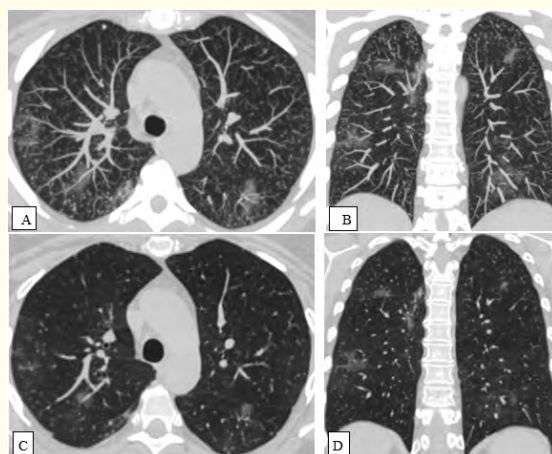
CT image of multiple bilateral areas of "ground glass opacity" and small foci of both lungs: A- Axial plane, MIP mode; B- Frontal plane, MIP mode; C- Axial plane, MPR mode; D- Frontal plane, MPR mode. Note: MIP (Maximum Intensity Projection) is the maximum intensity mode of the image. MPR (Multi-Planar Reconstruction) is the multi-planar reconstruction mode.
